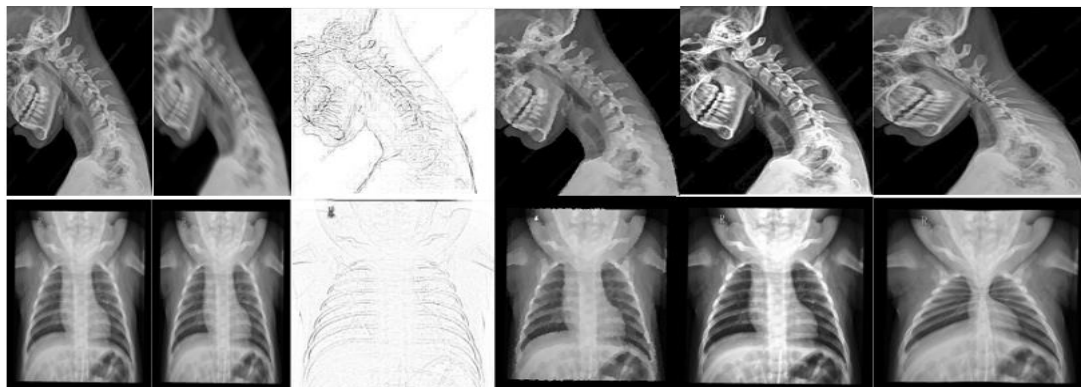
Neck and chest radiographic noise control; from left, original images,despeckled images, reduced noise images, transformed charcoal view images, embossed images and imploded images.
